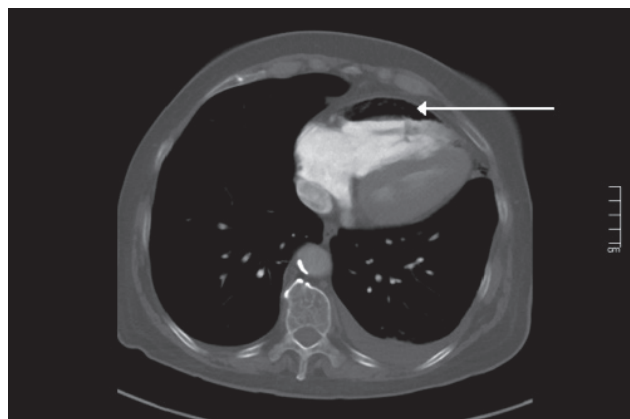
CT scan of the thorax showing intracardiac pocket of air (white arrow)
